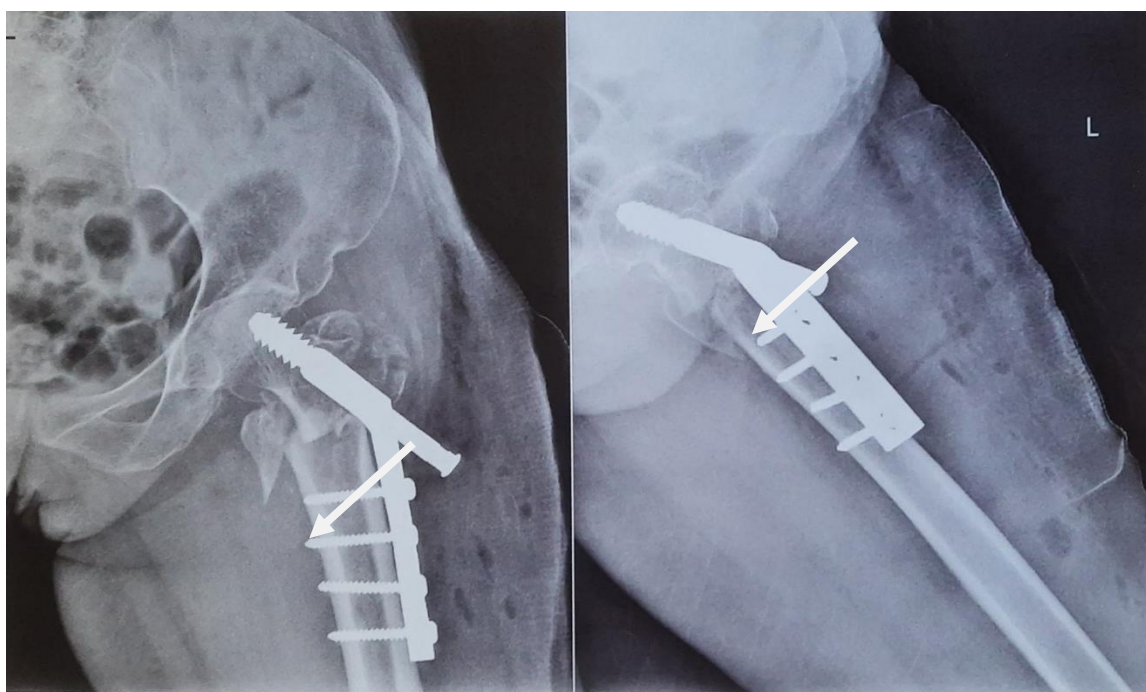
Post operative X-ray showing DHS in situ
